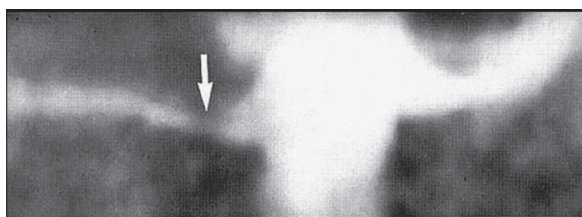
Computed tomography angiogram showing renal artery stenosis (arrow).
